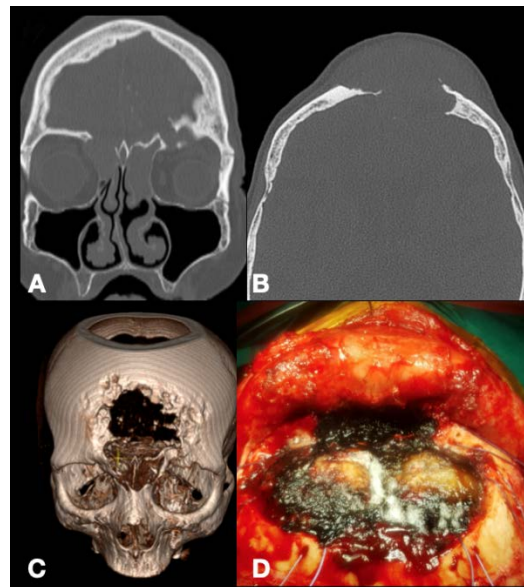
Preoperative coronal (A), axial (B), and 3D computed tomography (C) images of a patient diagnosed with inverted papilloma, along with the macroscopic view after tumor and attached dura were removed and duraplasty was performed (D).
